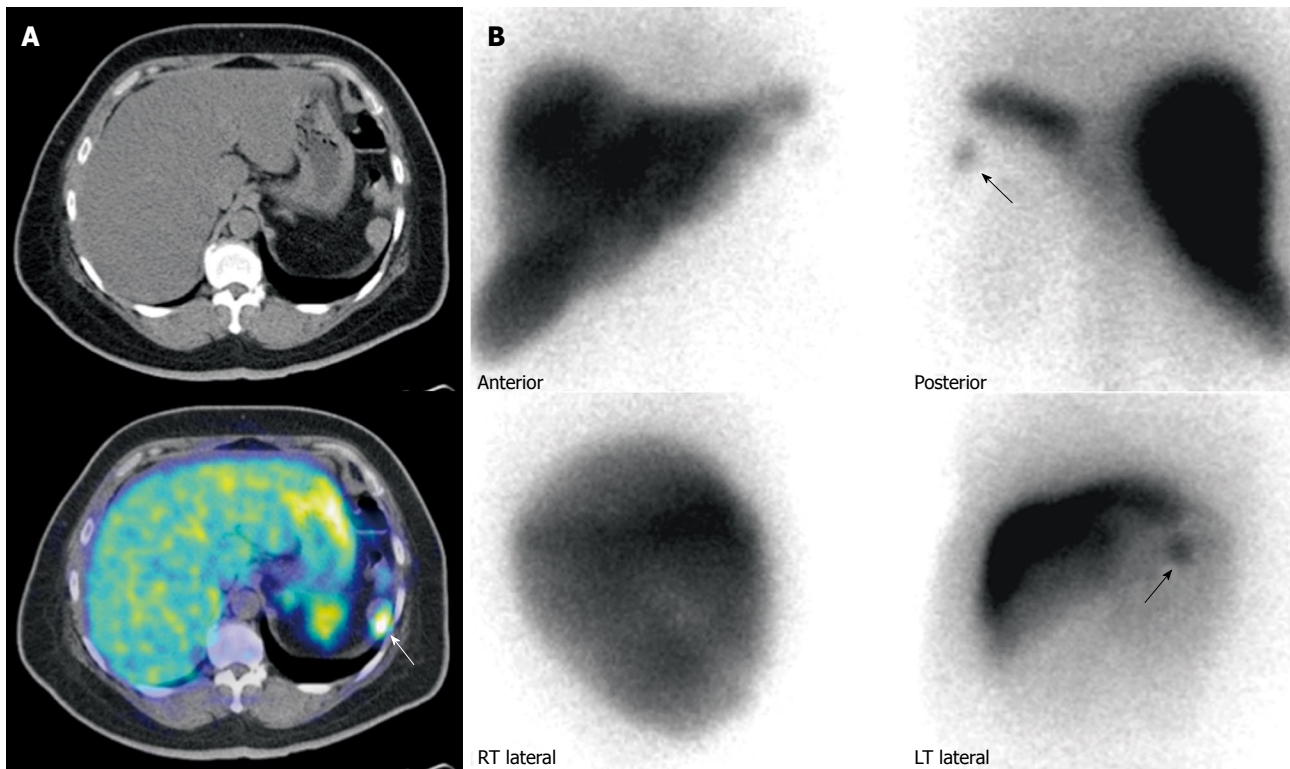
Patient with prior history of neuroendocrine carcinoma in the pancreatic tail, status post partial pancreatectomy and splenectomy. A: Gallium 68 DOTATATE positron emission tomography/computed tomography (PET/CT). Axial CT and fused PET/CT images of the abdomen shows a mass in the left upper abdomen demonstrating significant DOTATATE tracer avidity (white arrow). Considerations included tumor recurrence or splenunculus; B: Technetium 99m Sulfur Colloid scintigraphy. Anterior and posterior planar spot views of the upper abdomen demonstrates a focus of uptake (black arrows) in the left upper abdomen, corresponding to the area of uptake seen on the previous Gallium 68 DOTATATE scan, confirming the mass to be a splenunculus.
